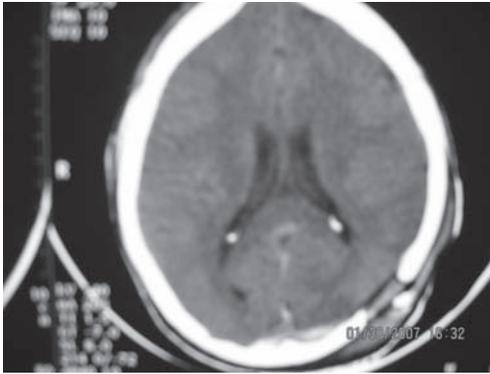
Post operative CT showing evacuation of EDH
